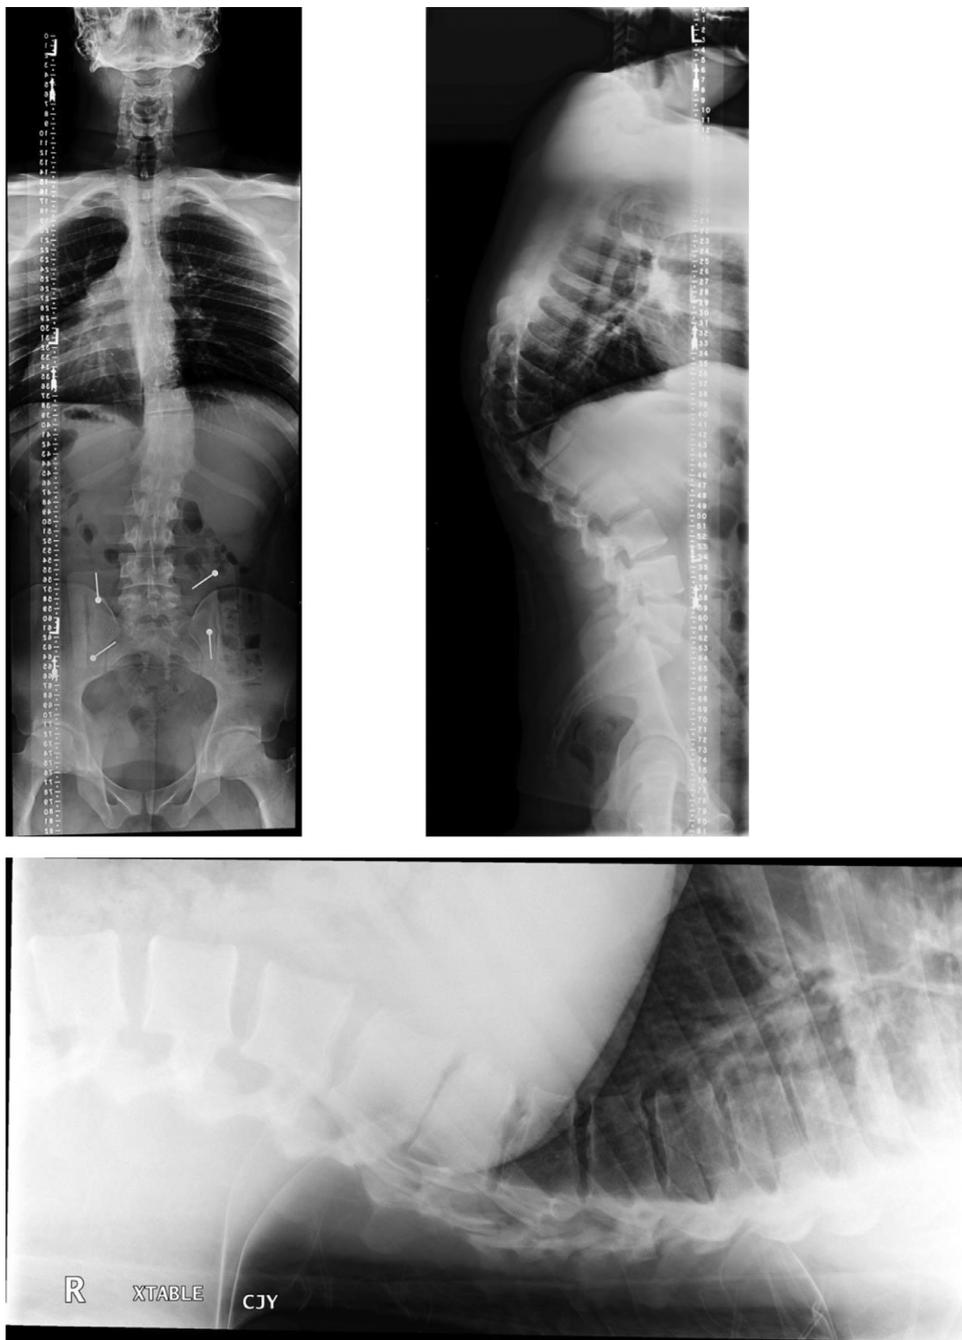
Standing radiographs of 21-year-old male with atypical Scheuermann kyphosis. Supine radiographs demonstrate spinal flexibility.
